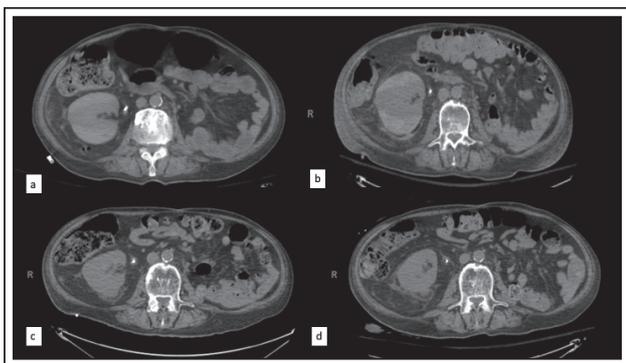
a) Image from patient's admission imaging showing a 9 cm SRH with an appropriately placed nephroureteral catheter with evidence of renal parenchyma compression. b) Repeat imaging on hospital day 7 shows the persistence of a stable SRH. c) Repeat CT 3 months later shows almost complete resolution of the SRH. d) Post-PCNL image with small residual SRH and stone-free.
